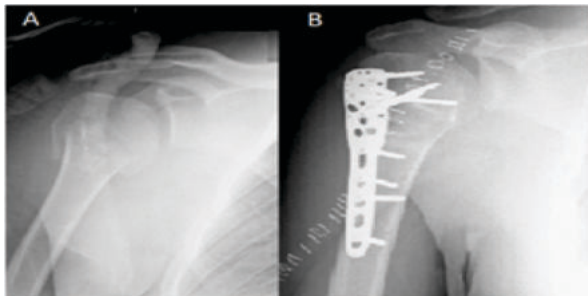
pre op and 2 months follow up x-ray.
